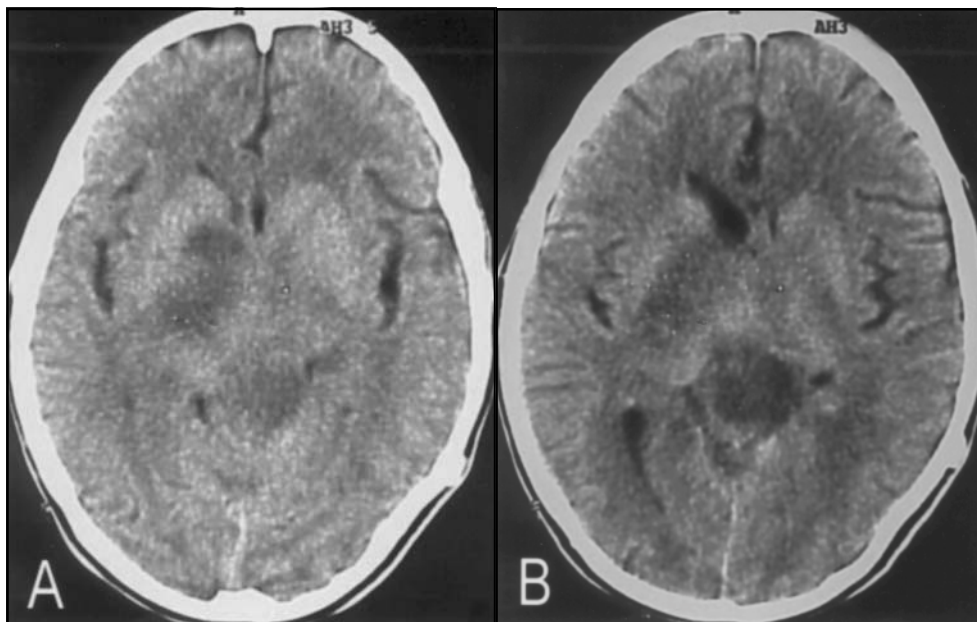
(A) and (B). Axial CT scan showing a hypodense ill-defined mass at the pineal region.
